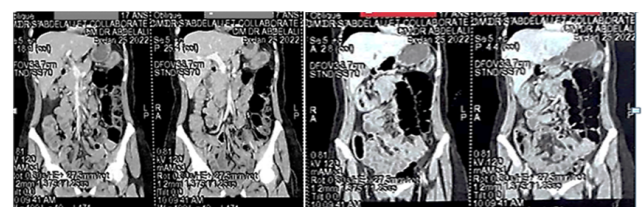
Enhanced CT scan of Abdomen. Coronal cut shows diffuse colonic thickening with reactive adenopathies.
